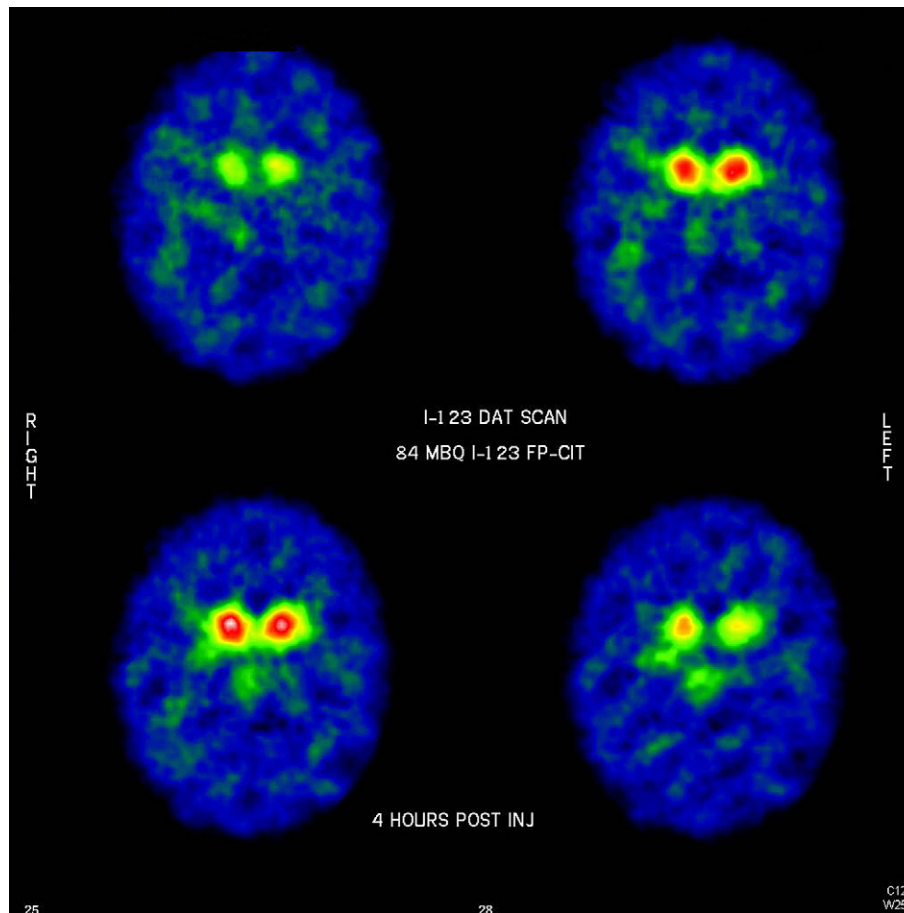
[^{123}I] SPECT scan of index case showing uptake of [^{123}I] in head of caudate nucleus bilaterally but marked symmetrical reduction of activity in lentiform nuclei bilaterally indicating diminished presynaptic dopamine transporter activity bilaterally.
